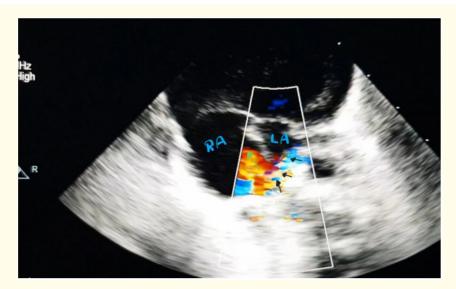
Color transthoracic echocardiography from subcostal view, LA: small left atrium, RA: wide right atrium, Green arrow: Blood flow across ASD, black arrows: Blood flow across pulmonary veins. It shows the direct flow from the normally connected pulmonary veins to the RA, because of the leftward malposition of the ostium primum.
